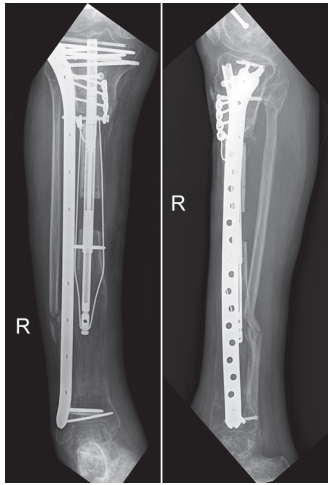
A/P and lateral radiographs of the right tibia demonstrating docking of the transporting segment with the pulley screw
